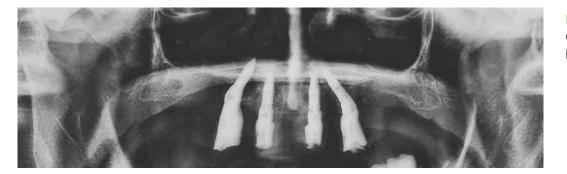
Radiographic evaluation after provisional steps.
